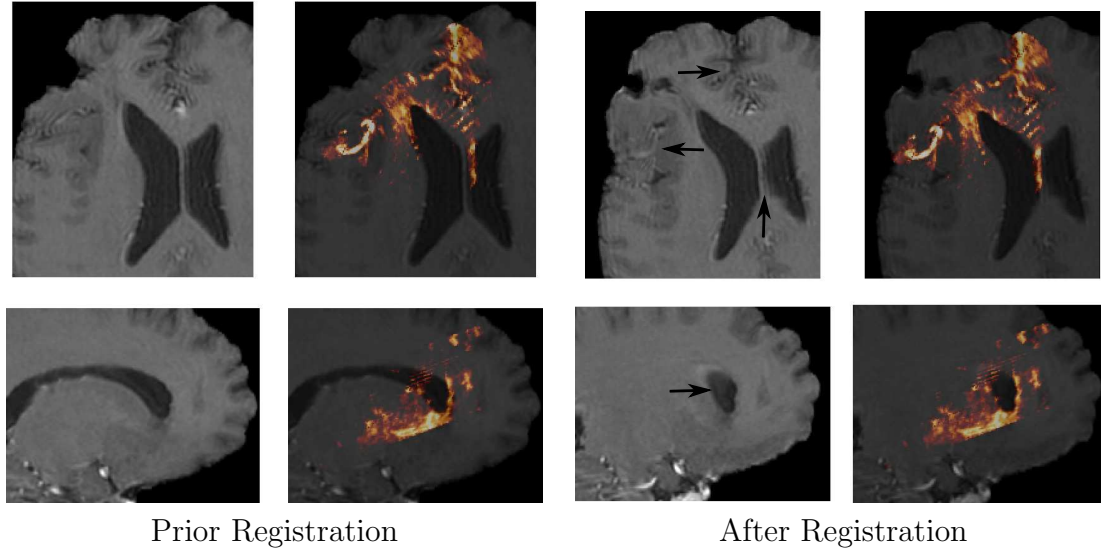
Registration results using clinical data from Patient 4 (see Table 3-4), with the non-overlaid Gadolinium-enhanced T1 MR images (Left) and overlays of the hot-metal toned dual-mode US on the MR images (Right) in both coronal (Top) and sagittal planes (Bottom) prior to and after registration. The TRE before registration is 3.75mm and 1.7mm afterwards. The arrows on the non-overlaid registered MR image indicate areas of improved alignment at the vessels, sulci, and ventricular borders through the use of our registration method.
